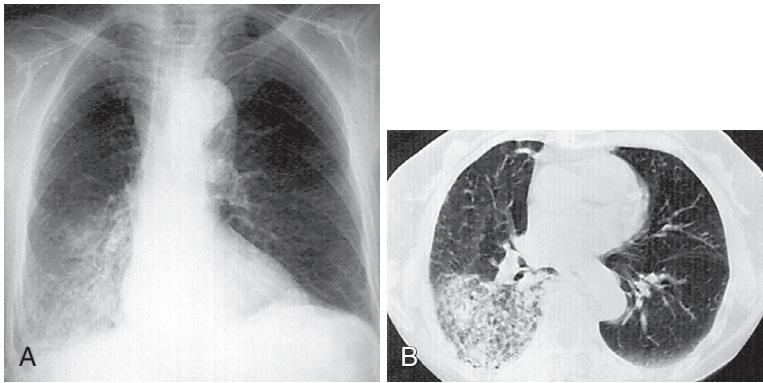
A and B, Consolidation in the right lower lobe, seen on front chest radiograph and computed tomography (CT), progressed despite antibiotic therapy. Biopsy proved bronchoalveolar carcinoma. (From Katz DS, Math KR, Groskin SA [eds]. *Radiology secrets*. Philadelphia: Hanley & Belfus, 1998, p 80, with permission.)
